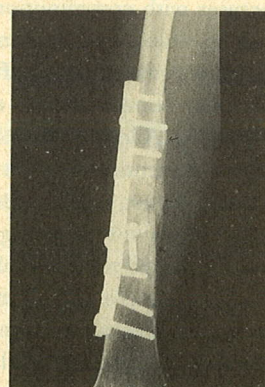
Post-operative radiograph of the same case at six months follow-up (AP and lateral views). Complete bridging of the fracture site with incorporation of allograft is seen.
